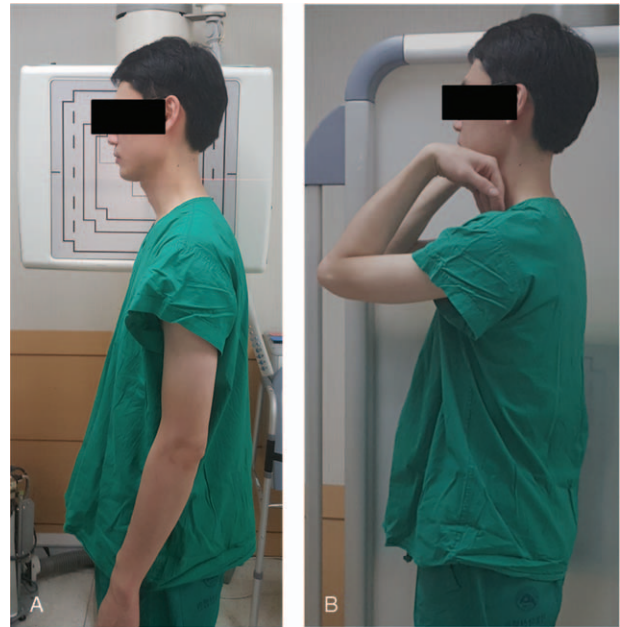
Cervical lateral radiograph obtained in a comfortable standing position with horizontal gaze and arms extended to the sides (A) and whole-spine lateral radiograph obtained in the hand-on-clavicle position with the elbows and wrist flexed, the fist relaxed, and the fingers placed into the supraclavicular fossa. Adopted from *Society* 20 Suppl 5:602–608. doi:10.1007/s00586-011-1927-y.
